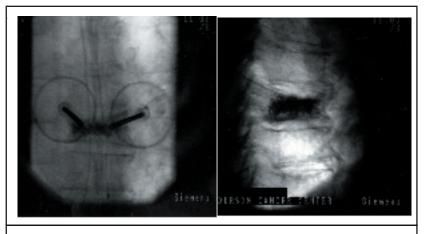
Anterior-posterior and lateral radiograph of lumbar vertebroplasty, after PMMA injection
